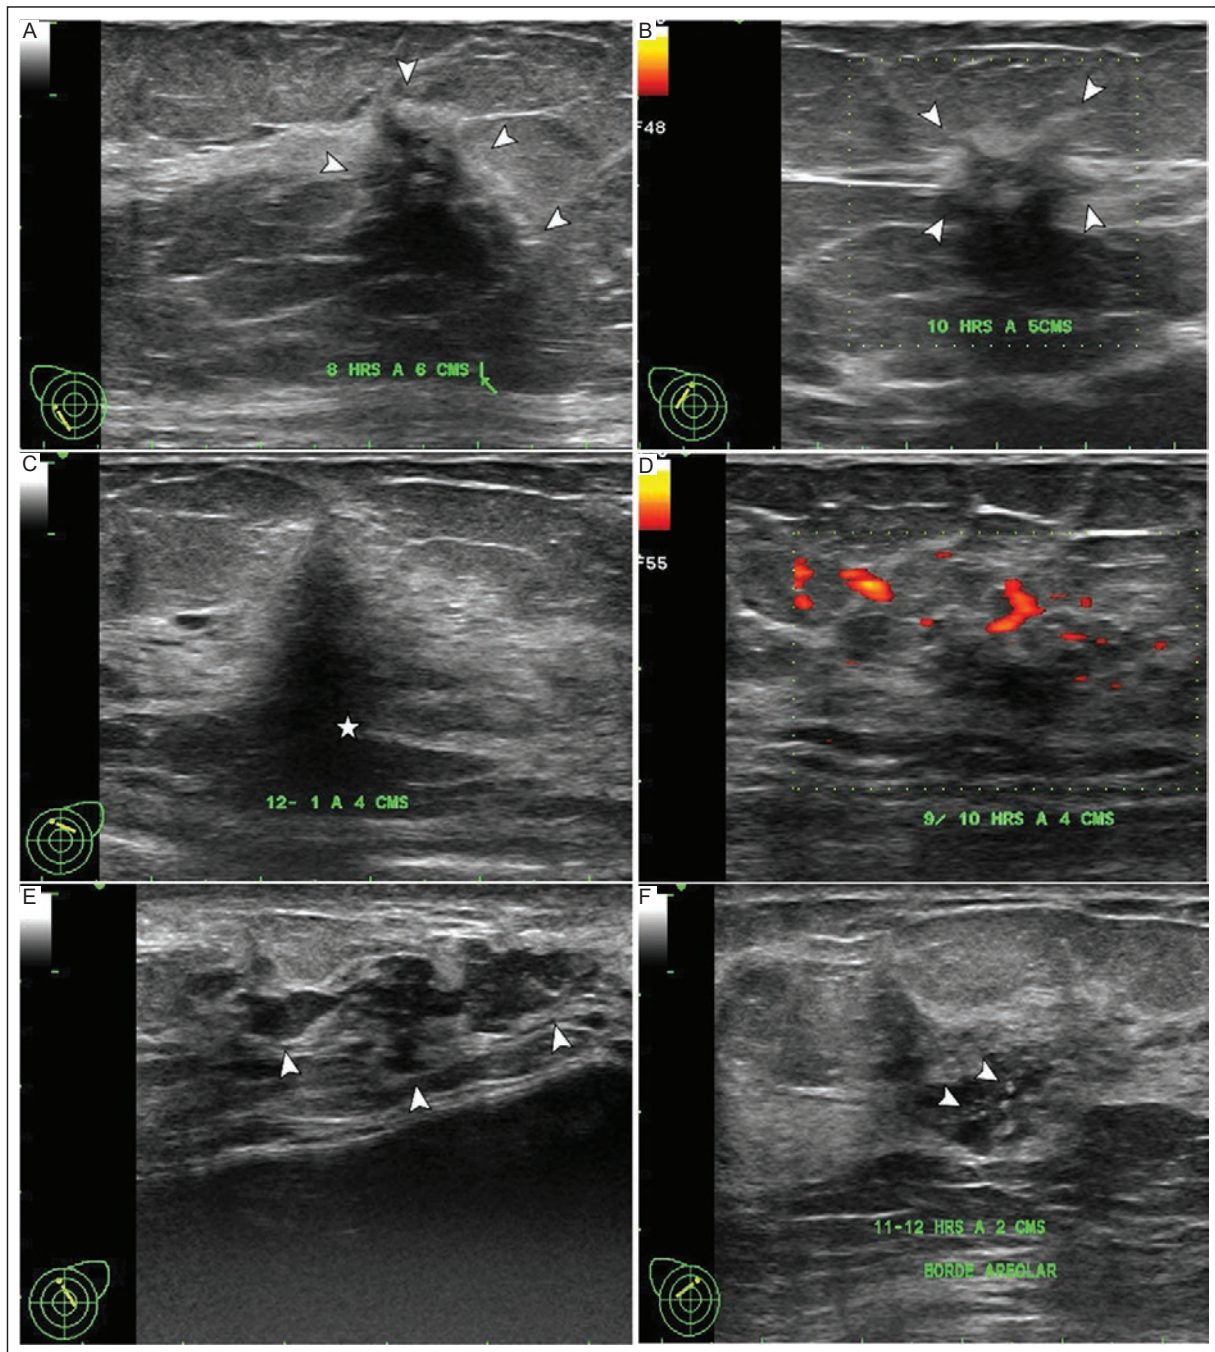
US in grayscale and power Doppler showing the associated findings of breast NM. A: echogenic rind (arrowheads). B: architectural distortion (arrowheads). C: posterior shadowing (star). D: Breast US power Doppler showing NM with hypervascularity. E: ductal extension (arrowheads). F: calcifications (arrowheads).
